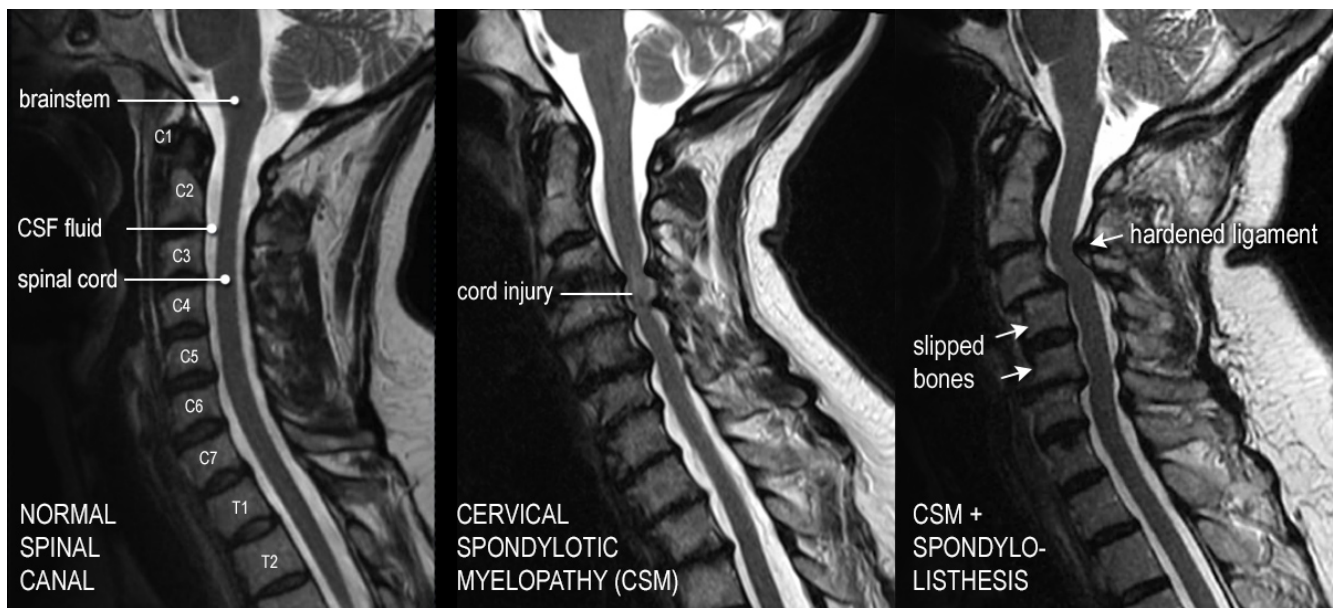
Side view of neck MRI. (Left) Normal spinal cord cushioned by CSF fluid in the spinal canal. (Center) MRI of stenosis pinching the spinal cord, causing myelopathy. (Right) MRI of CSM with bones slipping out of alignment.
